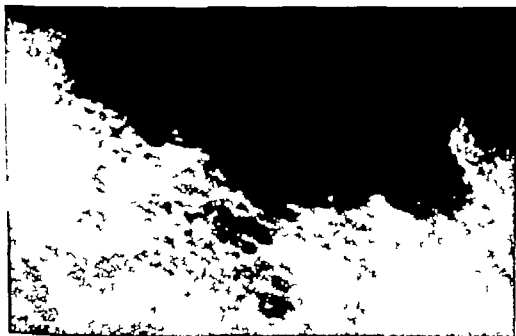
30—Intraoral roentgenogram of the patient shown in Fig 9 29. The characteristic lacelike appearance of the invading margin is seen.
